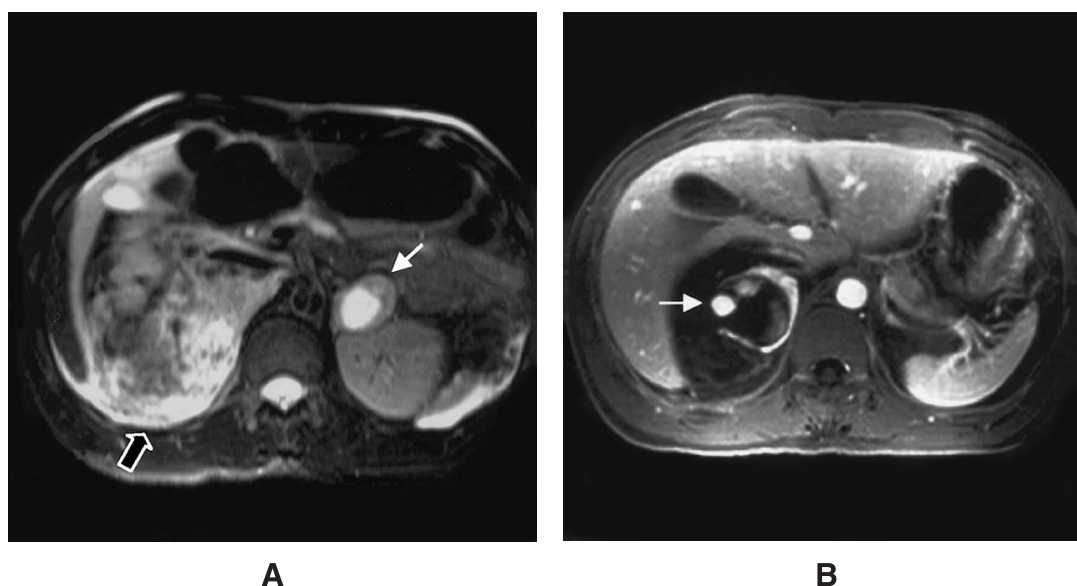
Abdominal MRI. (A) T2-weighted image shows heterogeneous high signal intensity (open arrow) suggestive of retroperitoneal bleeding around the right kidney, and also shows a 3.8 cm-sized high signal mass (thin arrow) in the left adrenal gland. (B) T1-weighted image after the injection of contrast media shows an aneurysmal enhanced vascular lesion (thin arrow) and areas of high signal intensity in the right adrenal mass.
